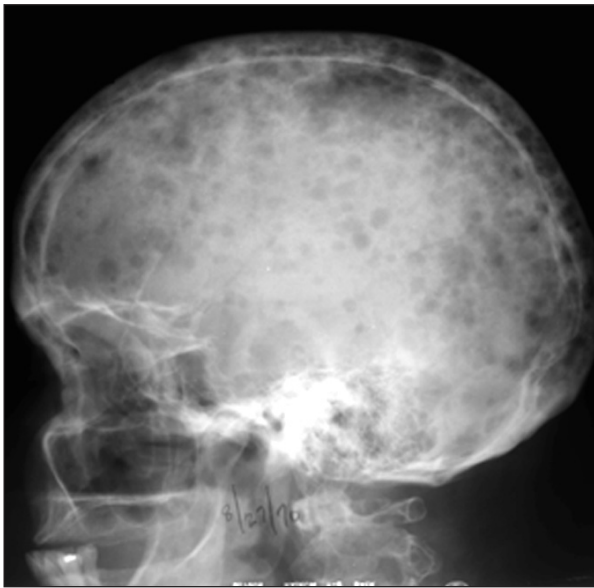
This lateral radiograph of the skull displays many punched-out, sharply defined lytic defects throughout the skull, as well as the cervical spine and mandible. The lesions do not seem to have a sclerotic border, and the foci spare the inner table of bone.
